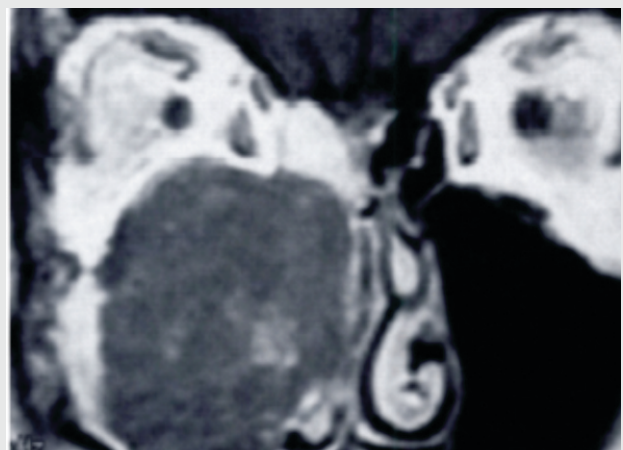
MRI, Coronal T1W sequence, plain image, tumour mass of right maxillary sinus, invading right nasal half and right orbit.
